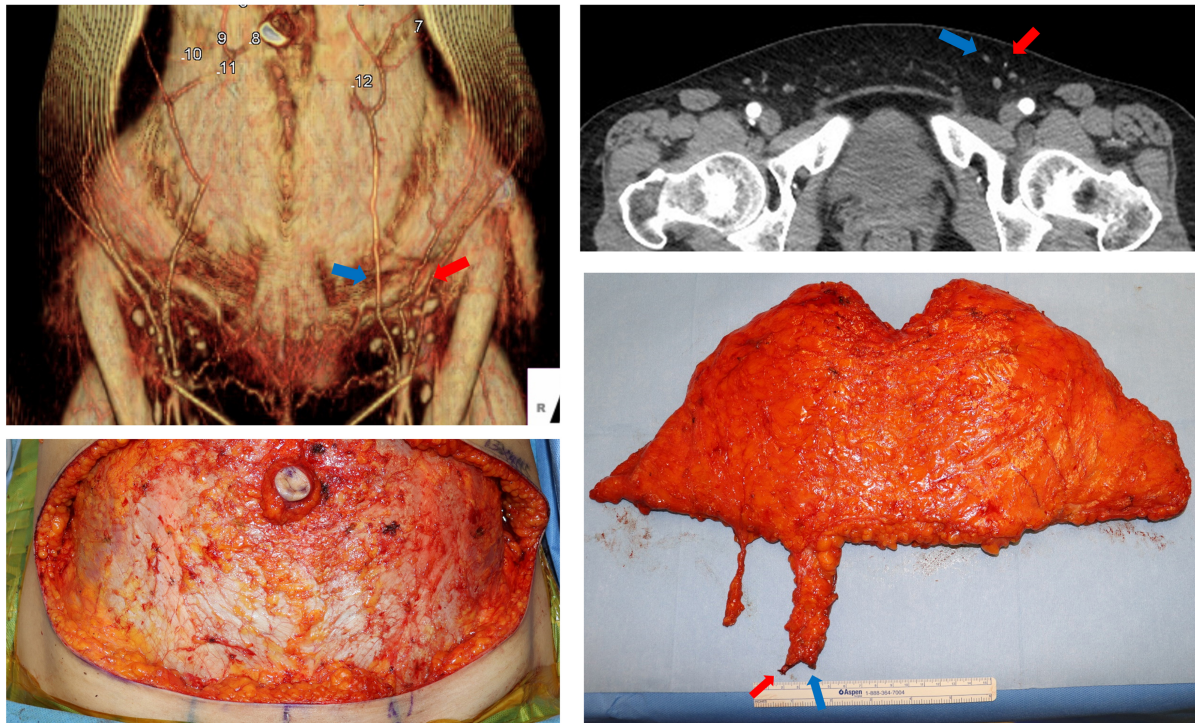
(Above) An SIEA flap was planned after identifying a suitable SIEA on preoperative CTA images. (Below) The course of the SIEA was traced on sagittal view images, and the flap was successfully harvested. Red arrow: SIEA; blue arrow: SIEV. CTA: Computed tomography angiography; SIEV: superficial inferior epigastric vein; SIEA: superficial inferior epigastric artery.
